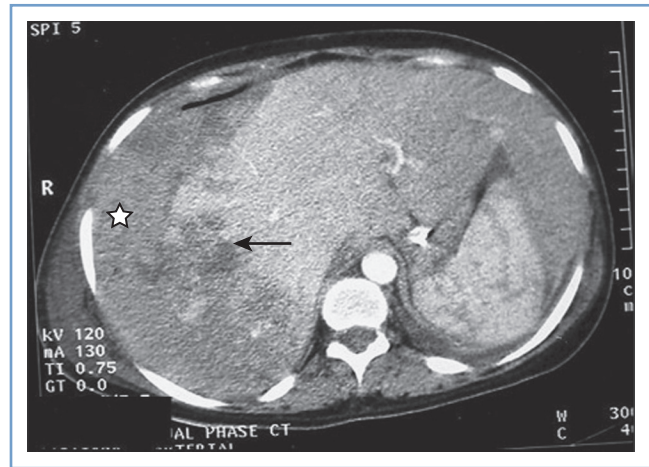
■ Contrast-enhanced computed tomography scan showing a large area of parenchymal hemorrhage with hepatic rupture (*arrow*) and subcapsular hematoma (*star*) in the right lobe of the liver. (From Das CJ, Srivastava DN, Debnath J, et al. Endovascular management of hepatic hemorrhage and subcapsular hematoma in HELLP syndrome. *Indian J Gastroenterol* 2007; 26:244-5.)
